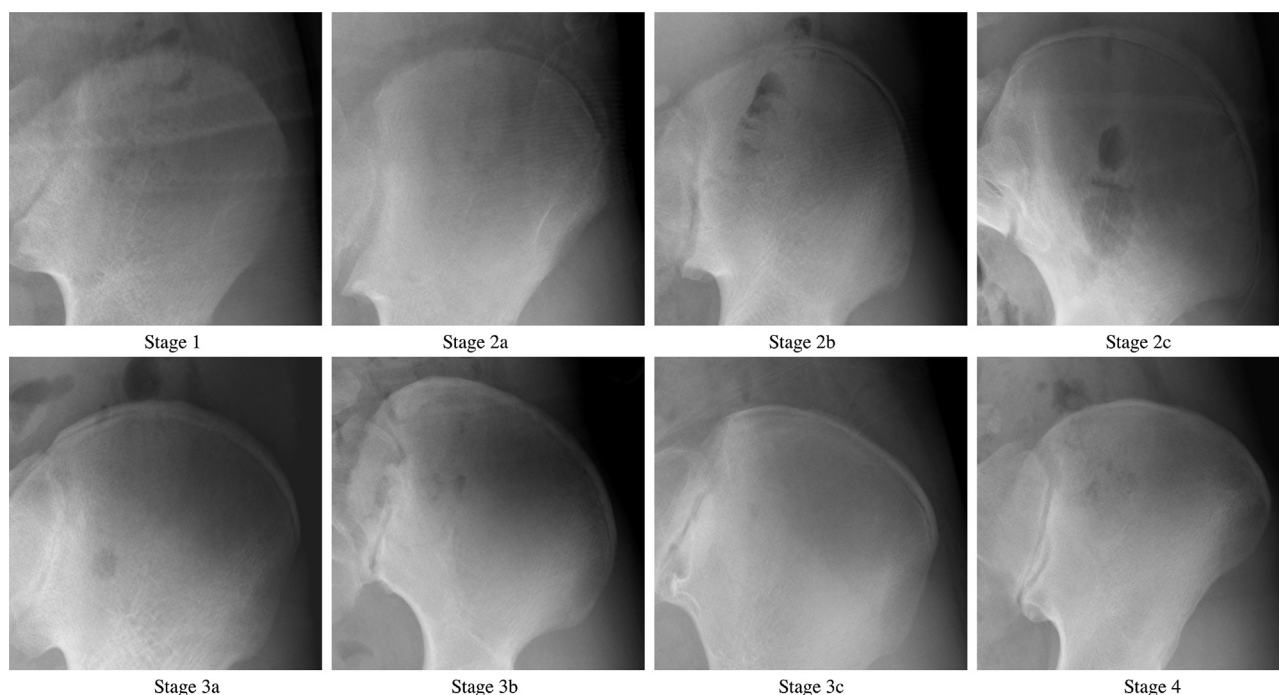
Ossification stages of the iliac crest and radiographic examples. Stage 1: Ossification centre not ossified. Stage 2a: Ossification centre ossified, the lengthwise apophyseal measurement is one third or less compared to the maximal lengthwise measurement of the iliac wing. Stage 2b: The apophyseal ossification extending into two thirds. Stage 2c: The lengthwise apophyseal measurement is over two thirds of the maximal lengthwise measurement of the iliac wing, the apophyseal cartilage has not ossified yet. Stage 3a: The apophyseal cartilage has partially ossified, the apophyseal fusion to the iliac crest is completed in one third or less. Stage 3b: The apophyseal fusion to the iliac bone is completed in over one third and less than two thirds. Stage 3c: The apophyseal fusion to the iliac bone is completed in over two thirds. Stage 4: Apophyseal cartilage has fully ossified.
